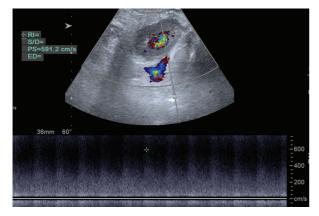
41-Year-Old Female Patient After Tru-cut Biopsy Patient has parenchymal lesion with yin-yang sign on Doppler ultrasonography and elevated peak systolic velocity with low resistive index on pulsed Doppler ultrasonography compatible with arteriovenous fistula.
